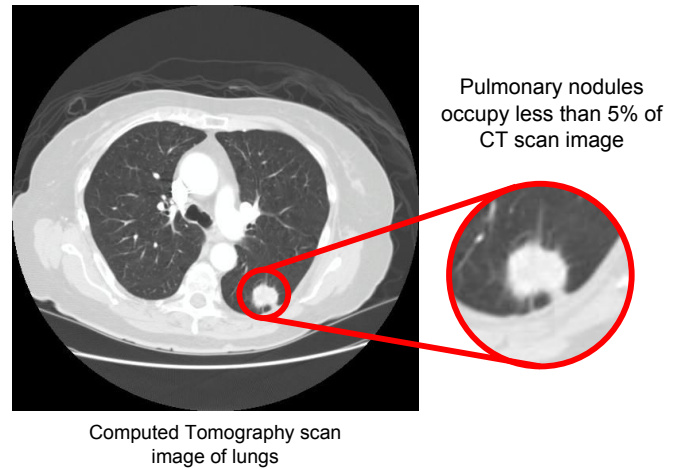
Pulmonary nodule in a CT-scan image
